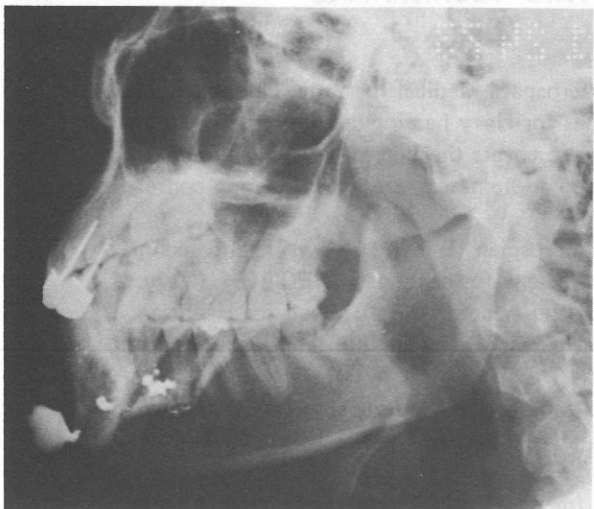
Right lateral oblique radiograph of mandible.
